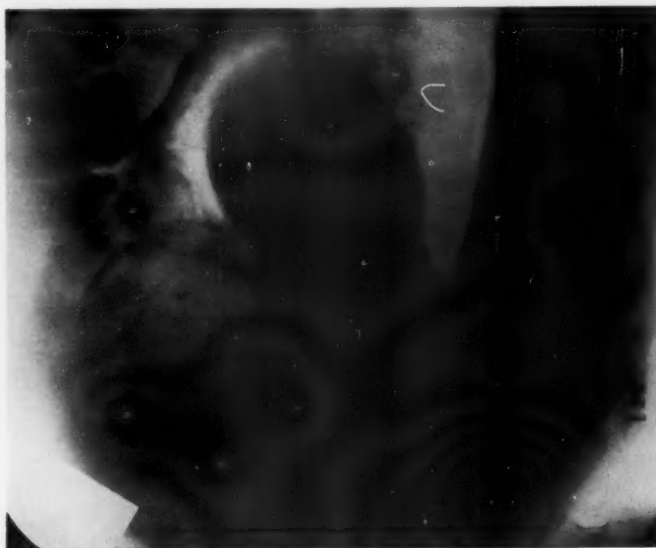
Roentgenogram taken somewhat higher than that shown in Fig. 2, and after more barium had been allowed to run into the colon. The size of the sigmoid is better shown. Some barium has now reached the ascending colon although the cecum contains only gas and non-opaque fluid.
